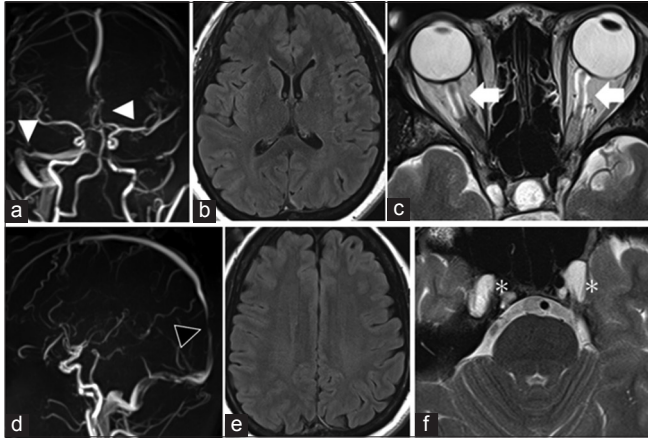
Magnetic resonance venography showed stenosis in the right transverse-sigmoid. (a) (White arrowheads) and in the superior sagittal sinus. (b) (Black arrowhead). On fluid-attenuated inversion recovery imaging, no ventricular enlargement or hydrocephalus is seen. (c and d). On T2-weighted imaging demonstrates accumulated cerebrospinal fluid in the bilateral optic nerve sheaths (white arrow). (e) And expansion of bilateral Meckel caves bilaterally (asterisk) (f).
